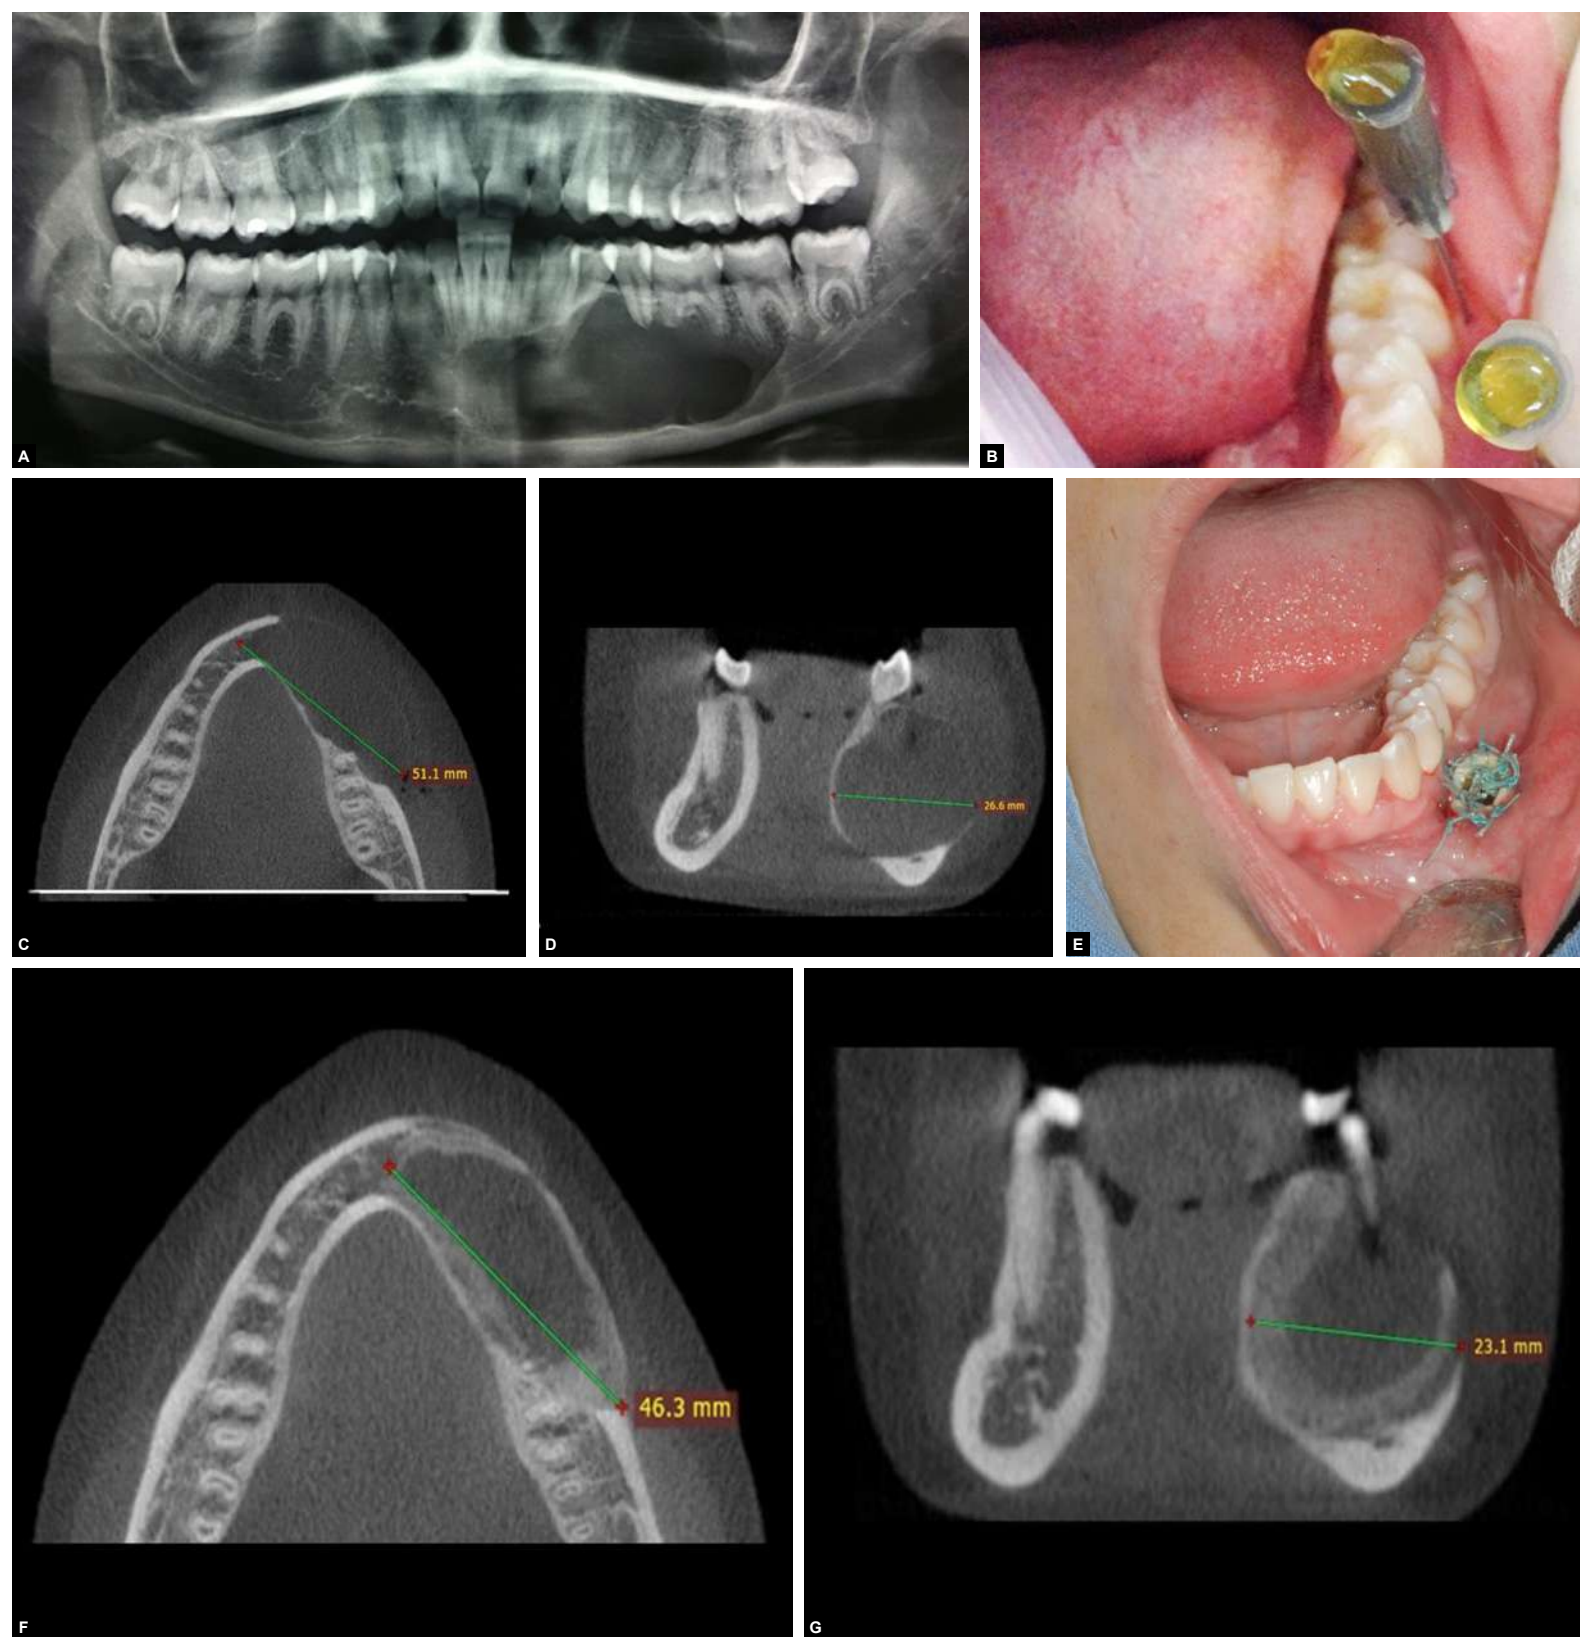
A) Radiolucent image involving dental elements from the region of the lower right incisor to the lower left second molar, with displacement and root resorption. B) Puncture image showing the presence of citrine fluid inside the lesion. C-D) Axial and coronal sections of the CT scan, showing the extent of the initial lesion. E) Image of the intraoral drain positioned for decompression of the lesion. F-G) Axial and coronal sections of the CT scan, showing the formation of reactive bone four months after decompression.
